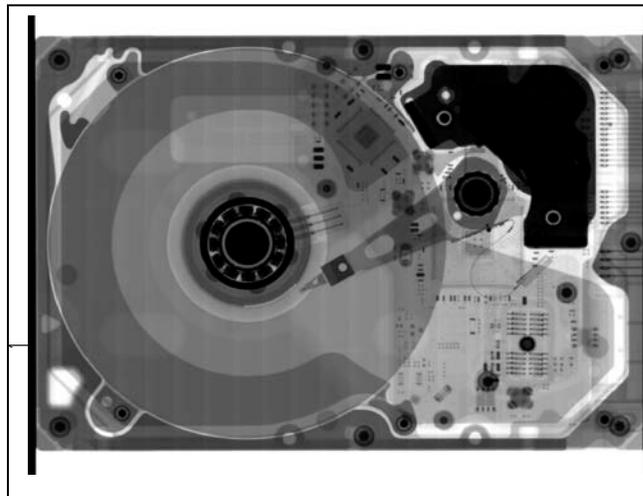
High resolution radiograph of the hard-drive.
